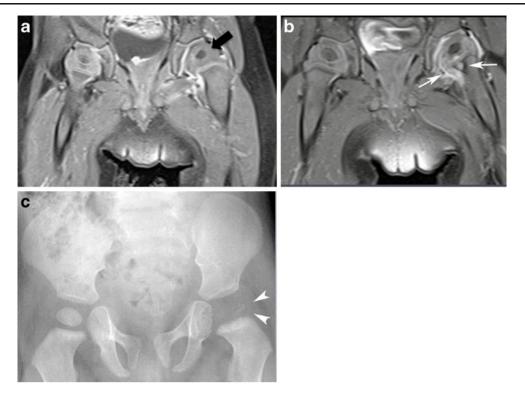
A 20-month-old with OAI of the left hip caused by GPC. a Contrast-enhanced T1-weighted fat-saturated coronal image shows lack of enhancement of the left femoral capital epiphysis (*black arrow*). b Repeat MRI after 2 months shows a transphyseal abscess
